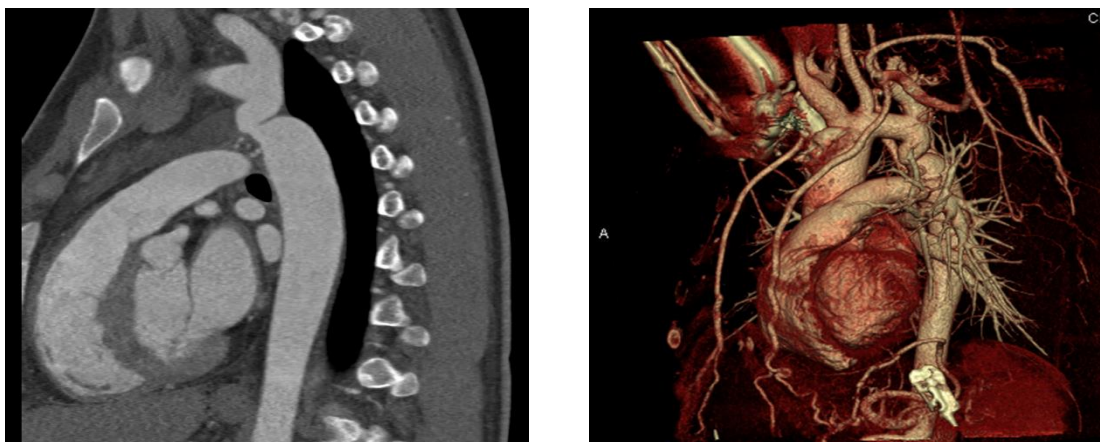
CT angiography of aorta showing coarctation distal to the left subclavian artery
